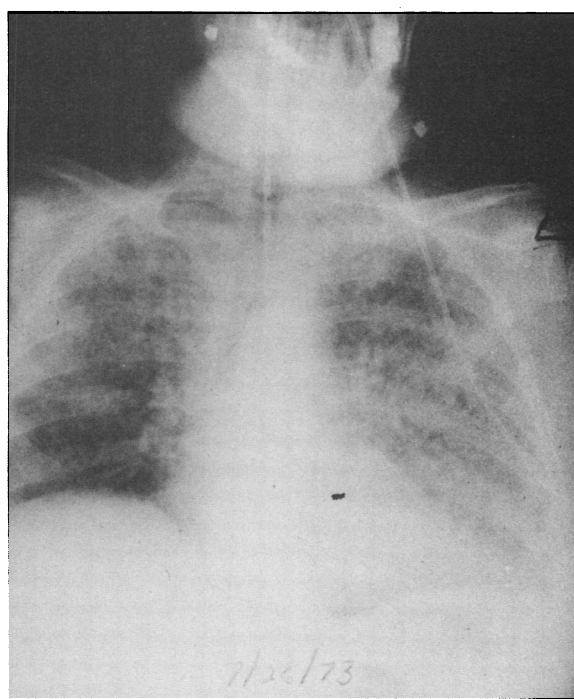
Roentgenogram of the chest showing a diffuse symmetrical alveolar infiltrate.
